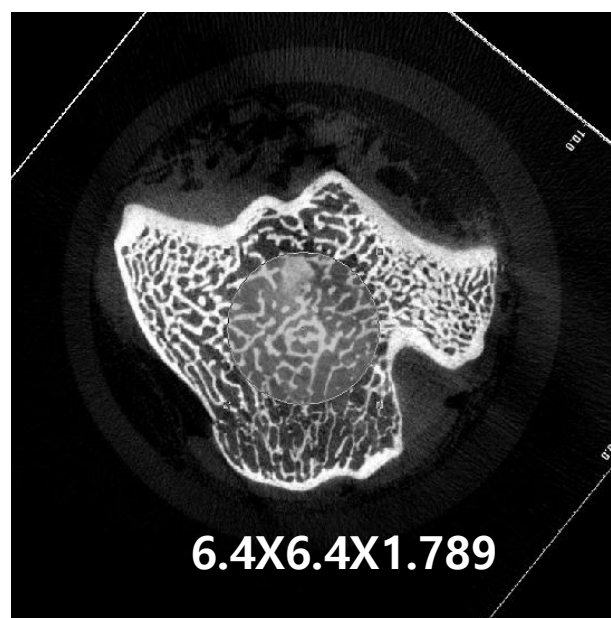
Volume of interest for evaluation of the osteoporotic changes in micro-computed tomography. The volume of interest (VOI) was selected as a column with a diameter 3.0 mm and a height of 4.507 mm (126 slices) which was defined as the maximal trabeculae bone region upper portion of the proximal growth plate of the tibia.
